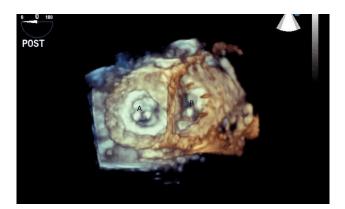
Three-dimensional transesophageal echocardiographic image of the Medtronic-Hall valves in the mitral (A) and tricuspid valve (B) positions.
